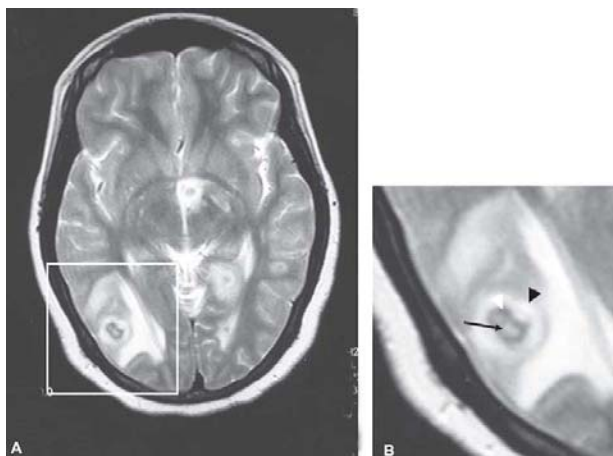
MRI of the brain [T2-weighted image, axial view] showing characteristic appearance of a tuberculoma [A]. Close-up view of the lesion showing central hyperintense area [solid arrow] suggestive of caseation necrosis; surrounding hypointense rim [white arrow head] of fibrous capsule; and a significant perilesional white matter oedema [black arrow head]
